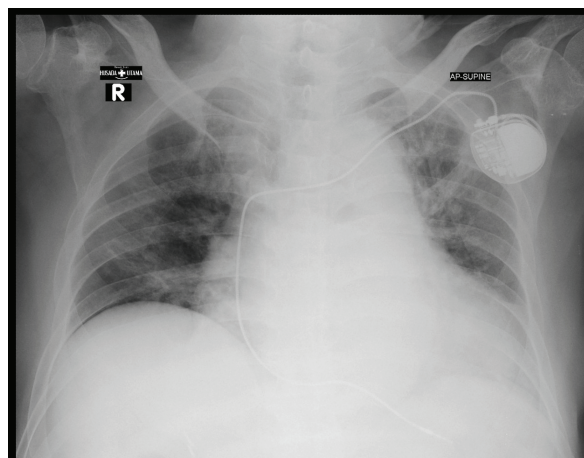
Pneumonia COVID-19 chest x-ray.
